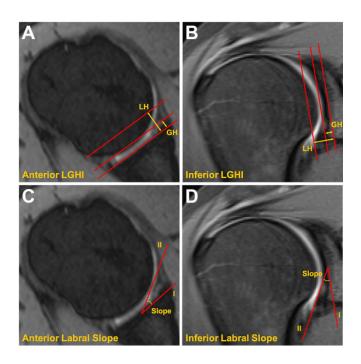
Magnetic resonance imaging T2-weighted slices showing the restored labrum. Labral glenoid height index (LGHI) indicates the quotient of labral height (LH) to glenoid height (GH). The labral slope refers to the angle between the tangent to the lowest portion of the glenoid (I) and the segment from the tip of the maximum labral height to the lowest portion of the glenoid (II). (A) Anterior LGHI. (B) Inferior LGHI. (C) Anterior labral slope. (D) Inferior labral slope.
